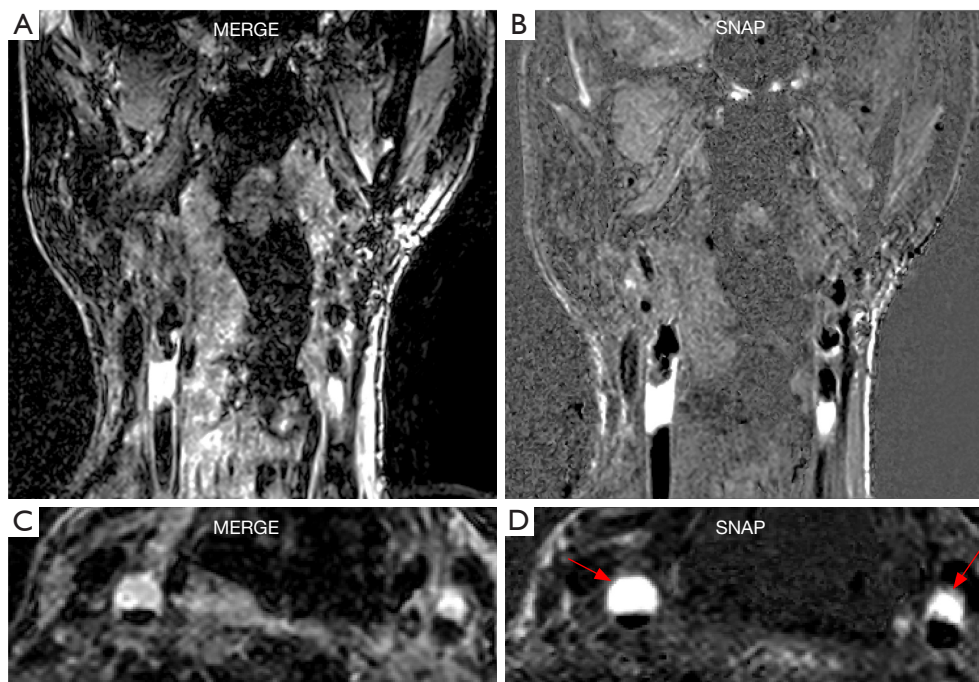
3D carotid vessel MR images were acquired at the Siemens scanner on one carotid atherosclerotic patient (male, 70 years old), with both coronal view (A,B) and re-formatted axial view (C,D) displayed. The vessel wall and plaque structures are clearly visualized in the 3D MERGE images (C), and IPH on both left and right carotid arteries can be depicted by the hyperintensity signals in the SNAP images (D, red arrows). These are consistent with the previous studies using Philips scanners. 3D, 3 dimensional; MERGE, motion-sensitized driven equilibrium prepared rapid gradient echo; MR, magnetic resonance; SNAP, simultaneous non-contrast angiography and plaque.
